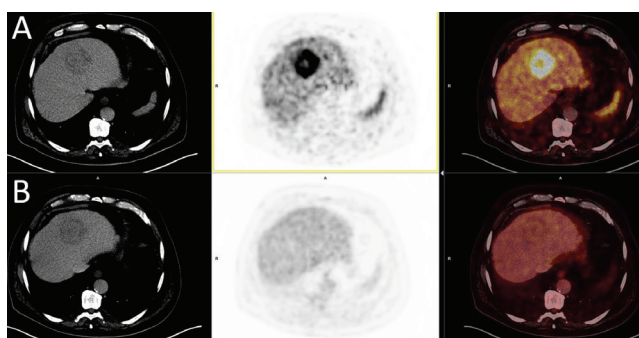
A 69-year-old male diagnosed with hepatocellular carcinoma (AFP: 4.5 ng/mL) by magnetic resonance imaging. The left lobe mass showed (A) an intense ⁶⁸Ga-PSMA (T/L: 4.49), while it showed no significant ¹⁸F-FDG (B) uptake (T/L: 1.01)
